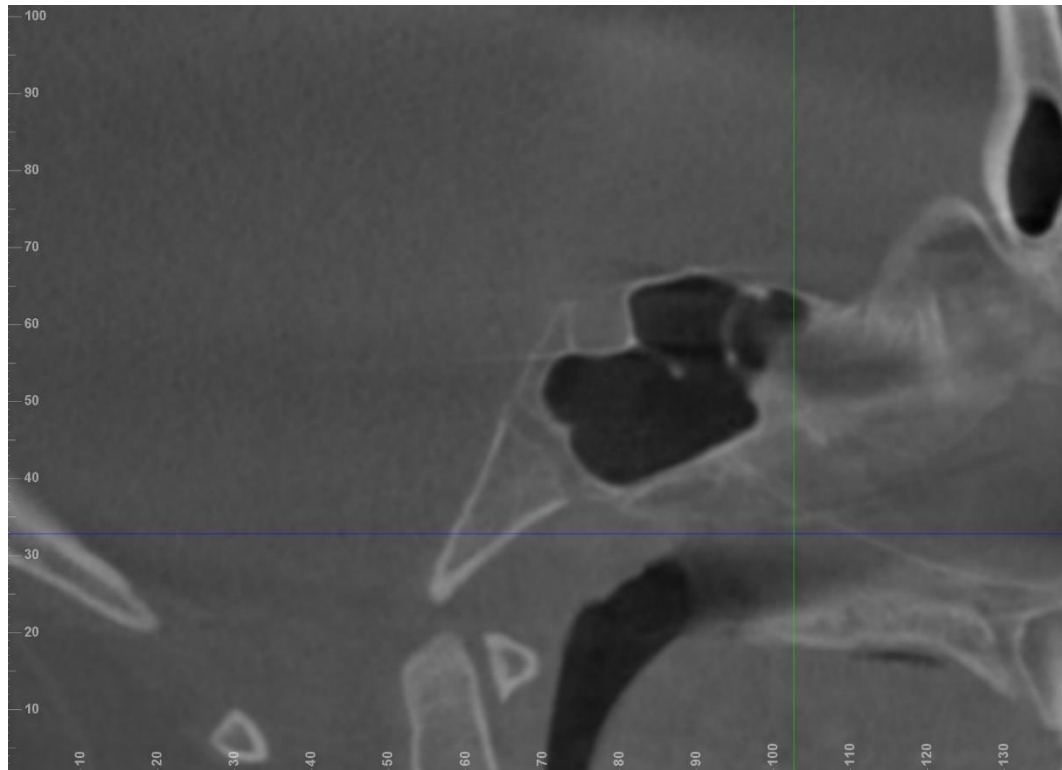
Example of Spheno-occipital synchondrosis radiograph
